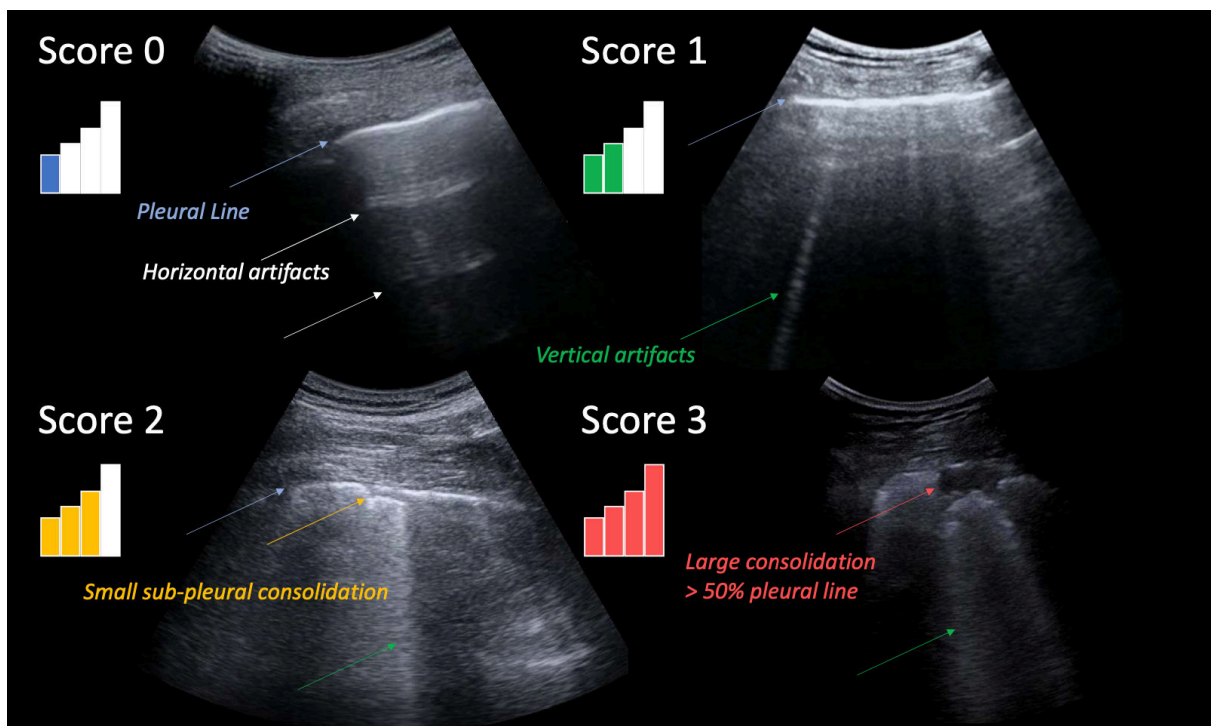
Typical LUS image associated with each level of the scoring system. A higher score is associated with a higher level of deaeration of the lung surface explored by ultrasound. A higher score is thus intended to signal a worsening of the status of the lung surface [1]. Relevant patterns are indicated by color-coded arrows. The displayed images were acquired with a convex probe.
